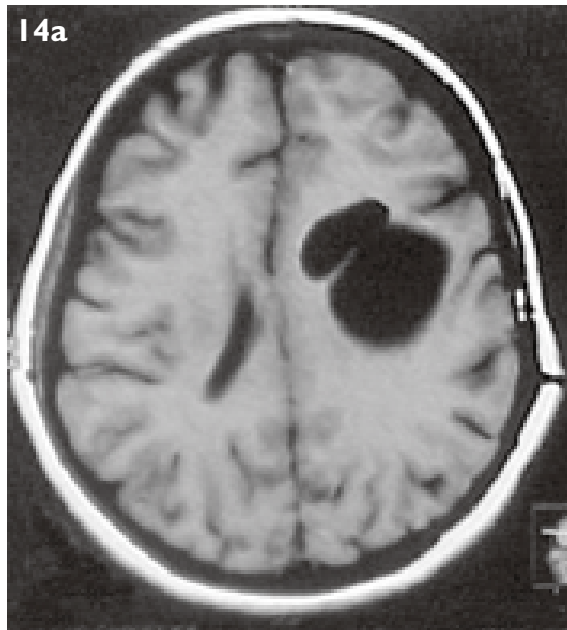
Cerebral hydatid disease. Axial (a) T1-W and (b) T2-W MR images of the brain show two cysts located adjacent to each other in the left parietal region. These show T1-hypointensity and T2-hyperintensity. The T2-W image shows a typical hypointense rim, characteristic of hydatid disease.
